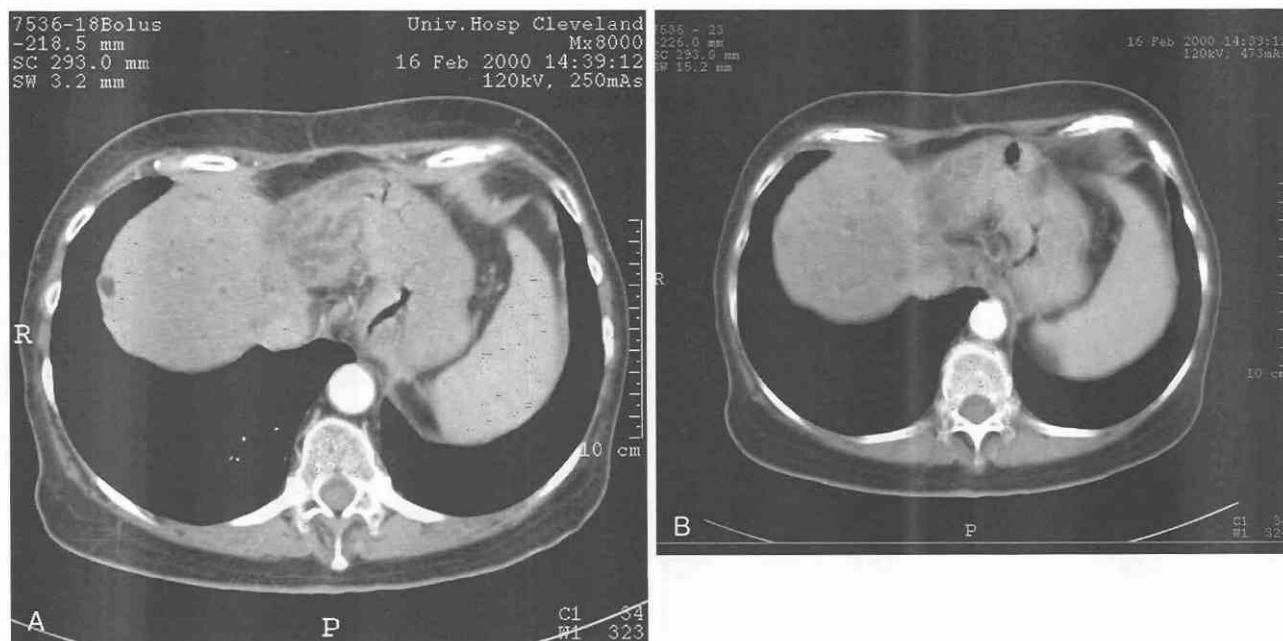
Liver scan representing enhanced lesion detection and reduced partial-volume artifacts in A (2.5-mm slice thickness) versus B (10-mm slice thickness). (Multislice CT image courtesy of Dr. John Haaga.)
